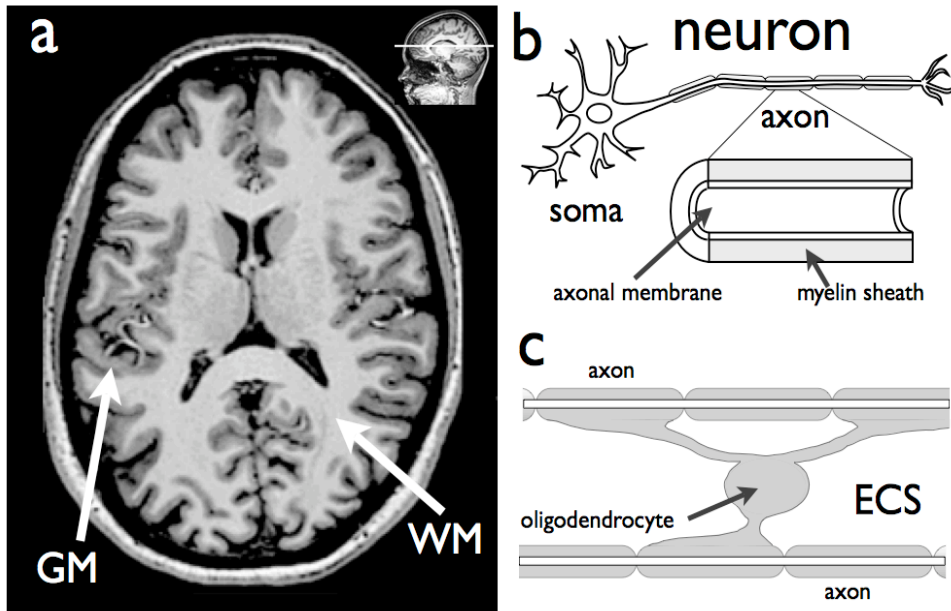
a) A typical MRI scan of the human brain showing locations of gray matter (GM) and white matter (WM). b) The gray matter predominantly consists of the soma of the neurons (b) while the white matter is formed by the myelinated axons of the neurons. c) In the central nervous system the insulating myelin sheath is created by oligodendrocytes. One oligodendrocyte may create more than one myelin sheath segment for several axons. Water molecules are present in the intracellular space (that is the space within the neurons and glial cells) as well as in the extra-cellular space (ECS)
